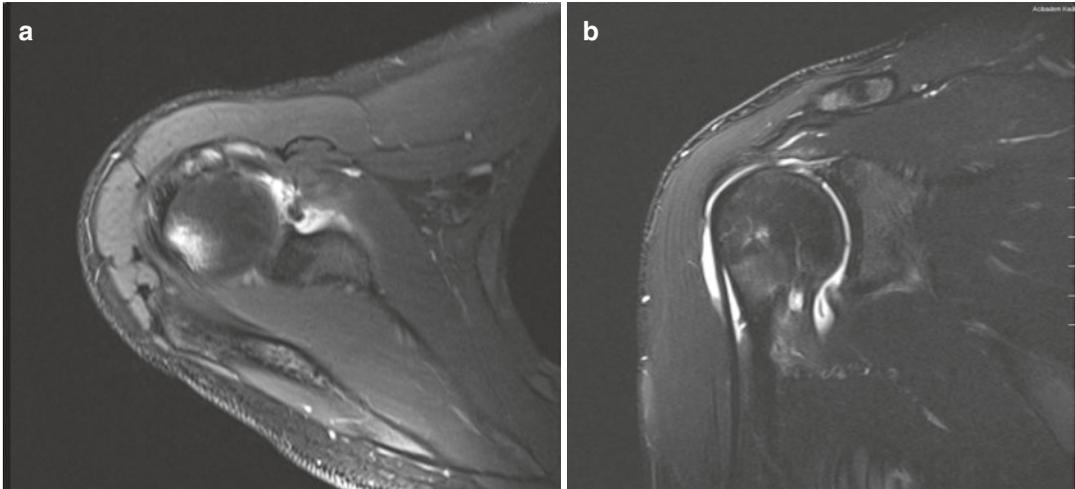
(a) Axial MRI view of traumatic SLAP lesion and labral tear. (b) Coronal MRI view of the same lesion
